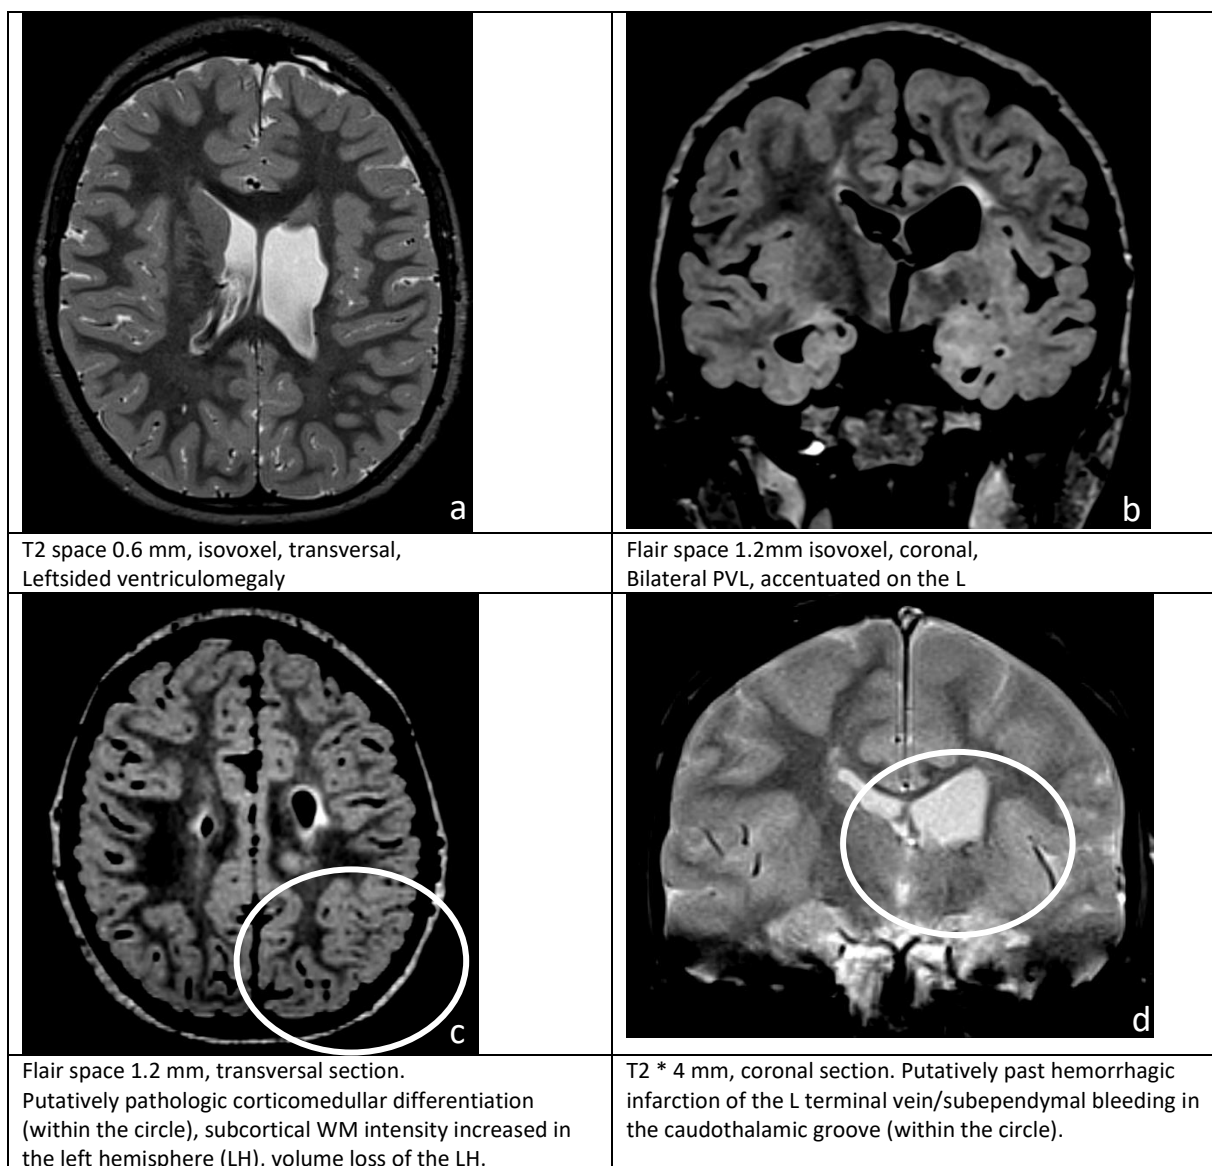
Preoperative MRI, Pat. 3, at age seven years.
